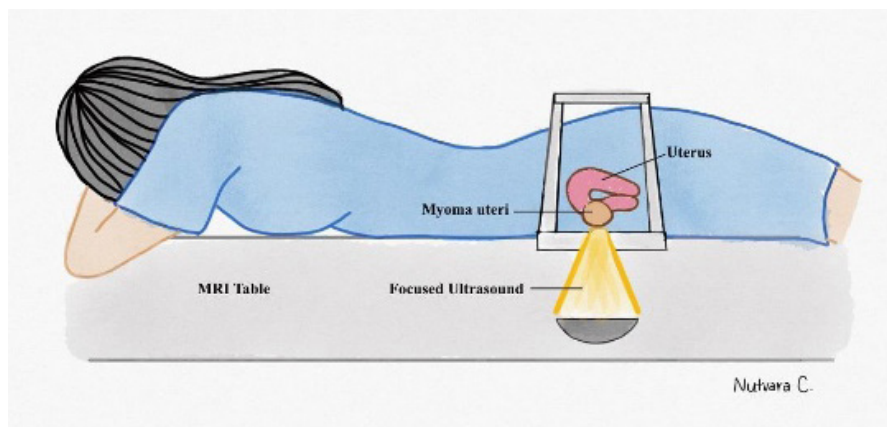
Magnetic Resonance-Guided Focused Ultrasound Surgery (MRgFUS)
